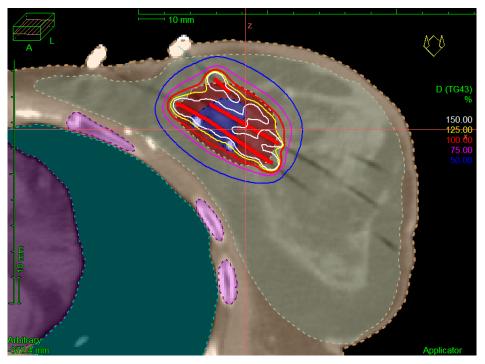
Conformal dose distribution on an axial CT slice.
